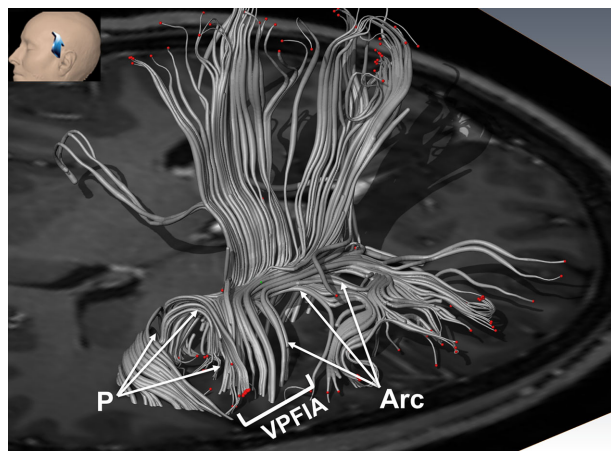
A and B, Diffusion tensor imaging tractography 3D reconstruction of the tracts that terminate at the ventral precentral fiber intersection area (VPFLA). C, T1 sagittal weighted magnetic resonance imaging with diffusion tensor imaging tractography reconstruction of the arcuate fasciculus, and pyramidal pathway terminating at the VPFLA. The anterior segment of the arcuate fasciculus terminates at the posterior portion of the VPFLA. The intermediate part of the VPFLA is occupied by the long segment of the arcuate fasciculus. The pyramidal pathway terminates at the anterior portion of the VPFLA. D, Detailed view of the image presented in C. A-Arc: Anterior segment of the arcuate fasciculus; CS = Central sulcus; L-Arc: Long segment of the arcuate fasciculus; P = Pyramidal pathway; SF = Sylvian fissure.
